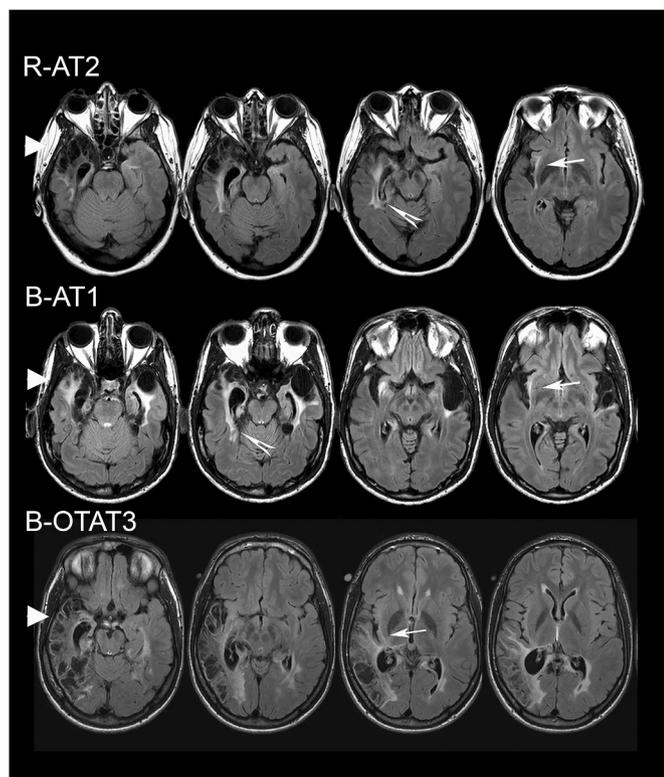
Close-up views of relevant axial FLAIR MRI sections in patients with amusia. Left-most sections show the damage to the right anterior temporal poles (triangular arrowheads) and amygdalae. White arrows with tails point to the hyperintensities in the right insulae. White arrows without tails in R-AT2 and B-AT1 point to hyperintensities in the white matter of the inferior aspect of the right superior temporal gyri. B-ATOT3 has substantial damage to the right superior temporal gyrus, as seen in right three sections.
